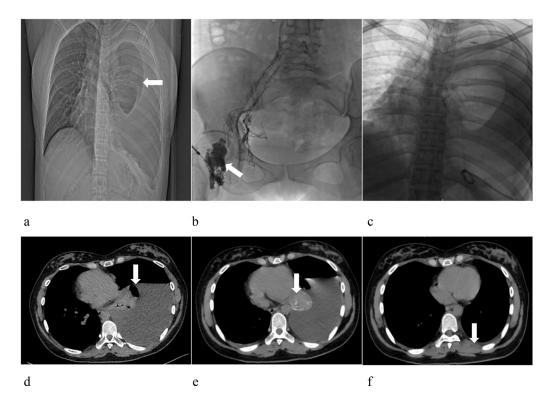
(A) Chest X-ray showing significant pleural effusion on the left side. (B) Ultrasound-guided puncture of the right inguinal lymph node. (C) Intraoperative DSA image of the thoracic duct. (D) Chest CT image upon admission. (E) Chest CT image on the first day postoperation.
